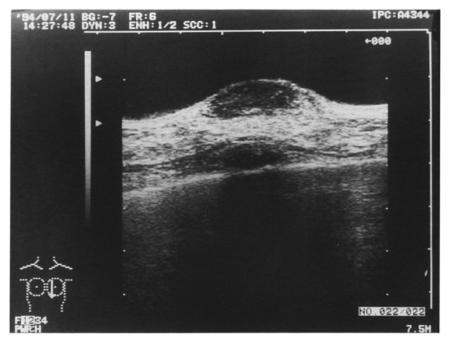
Ultrasonography showed a well-delimited, hypoechoic tumor shadow. There was no evidence of intraductal spread or any other tumors.
